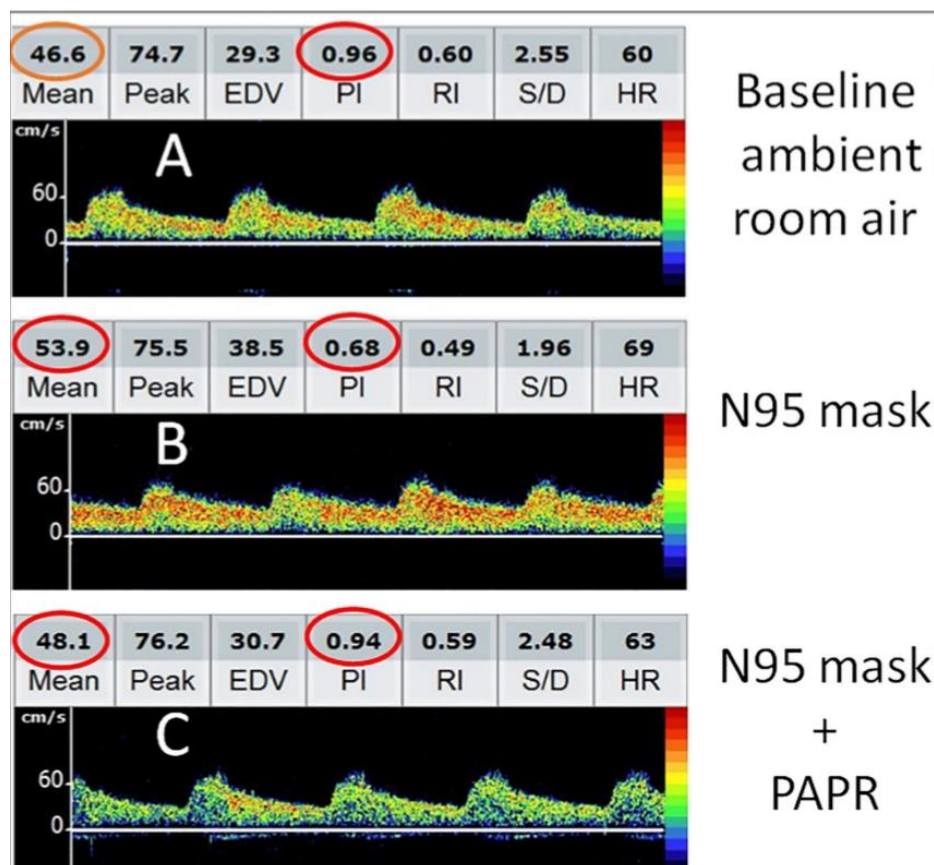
Serial transcranial Doppler (TCD) changes during donning of N95 respirator mask alone and together with powered air purifying respirator (PAPR). While breathing ambient room air, Doppler spectra from right middle cerebral artery showed mean flow velocity (MFV) 46.6 cm/s and pulsatility index (PI) 0.96 (A). After donning N95 respirator mask for 5-minutes, MFV increased to 53.9 cm/s while PI decreased to 0.68 (B). However, both MFV and PI returned to near-baseline 5minutes after donning PAPR and N95 respirator mask together (C).
